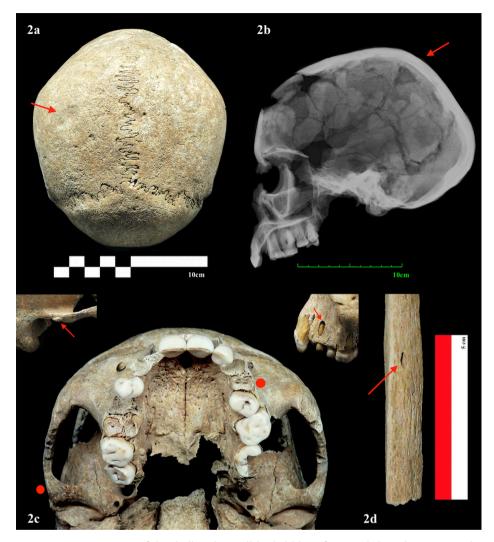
a: Posterior view of the skull with a well-healed blunt-force oval-shaped trauma on the left parietal bone (arrow); b: X-ray image in latero-lateral projection of the skull. The arrow points to the diploic thickening of the cranial vault; c: Inferior view of the skull showing the individual's dental condition (maxillary region). The dots indicate the location of the lesions highlighted by the arrows. *Left arrow*: detail of the right zygomatic arch with new bone formation; *right arrow*: detail of an apical granuloma in the left first premolar; d: Mid-shaft of the left radius. The arrow indicates an oval-shaped osteolytic lesion.
